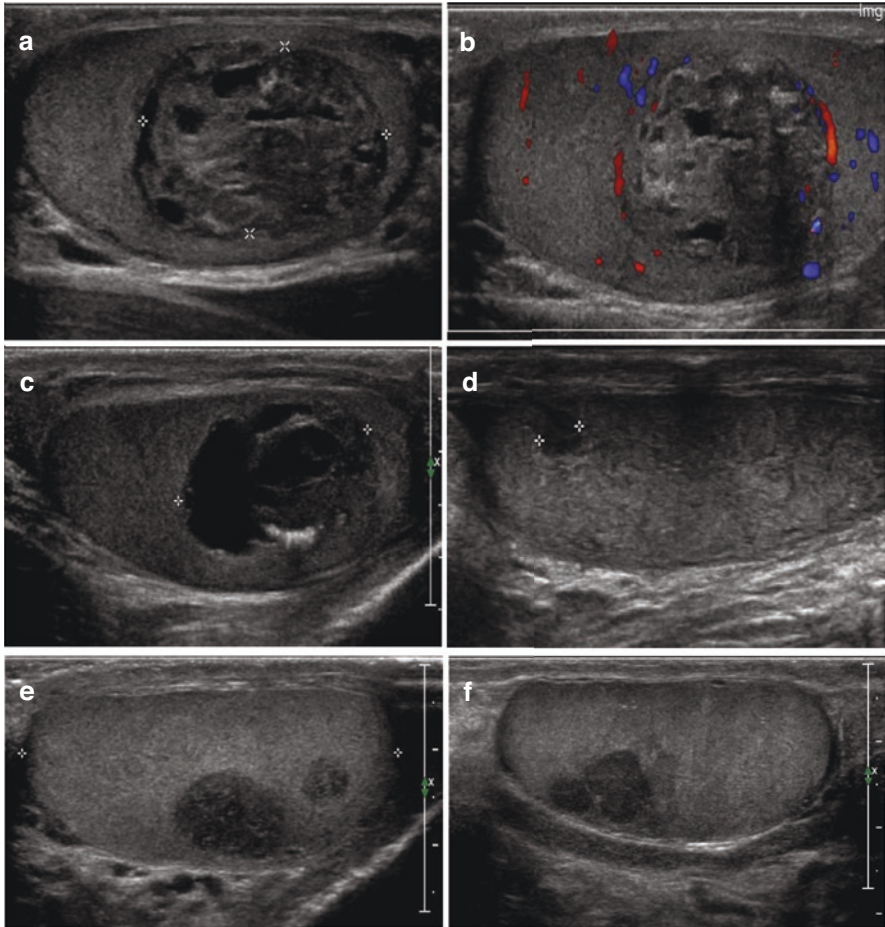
Examples of ultrasound examinations of testicular neoplasia in children and adolescents. (a, b) Mature post-pubertal teratoma, in a 16-year-old patient, appearing as a complex solid lesion, with cystic components and hyperechoic spots, in (b) peripheral vascularization on colour Doppler ultrasound examination, (c) Post-pubertal teratoma with epithelial malignancy in a 14 years old, appearing as a complex, predominantly cystic lesion with a solid component and hyperechoic foci with acoustic shadowing, (d) Leydig cell tumour in a 10 years old, appearing as a well-demarcated small, hypoechoic and homogenous lesion, (e) Multifocal pure seminoma in a 15 years old, appearing as hypoechoic and homogenous solid lesions, (f) Pure seminoma with polycystic lobulated margins in a 14 years old
